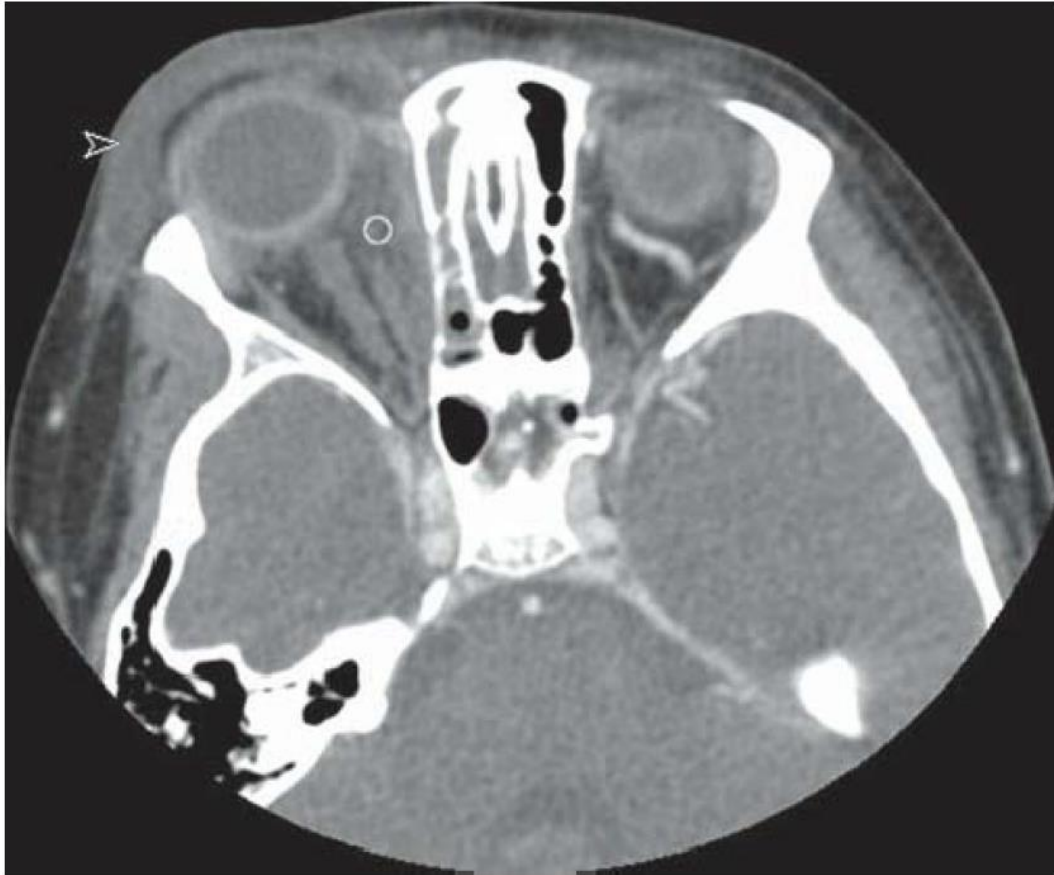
Axial CT scan showing right orbital cellulitis with diffuse orbital inflammatory changes that are intra- and extraconal (*open circle*); there is concurrent preseptal edema and inflammatory changes (*arrow*).
